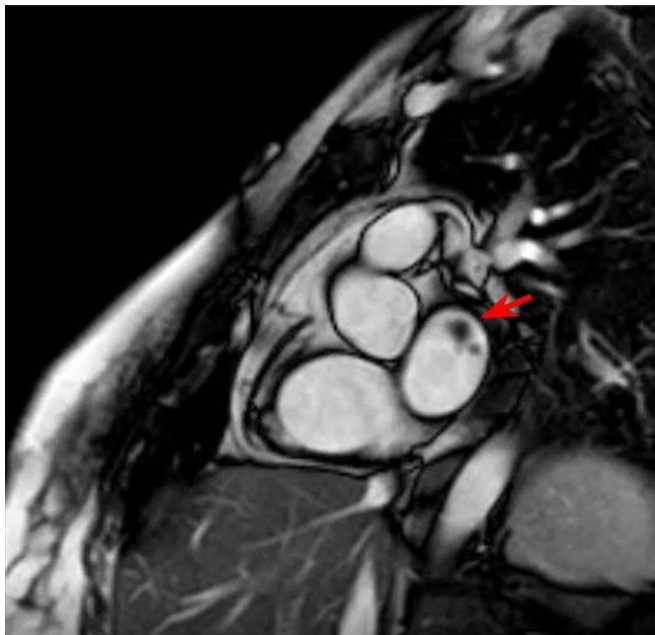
Cardiac MRI IT attached by pedicle to posterior free wall of atrium.
